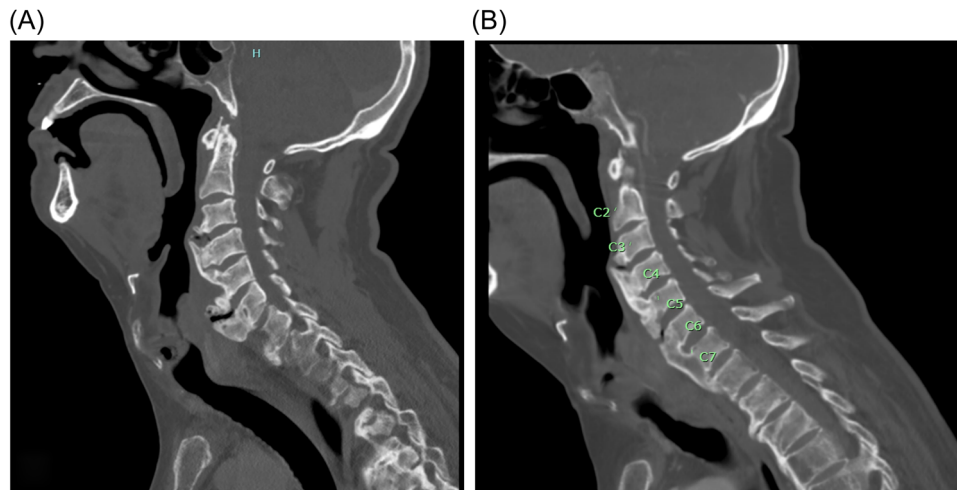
Patient 4 sagittal CT scan of DISH. (A) Preosteophyte removal demonstrates cervical spine hyperostosis over C4-T1. (B) Postosteophyte removal of C5-C6. CT, computed tomography; DISH, diffuse idiopathic skeletal hyperostosis.
